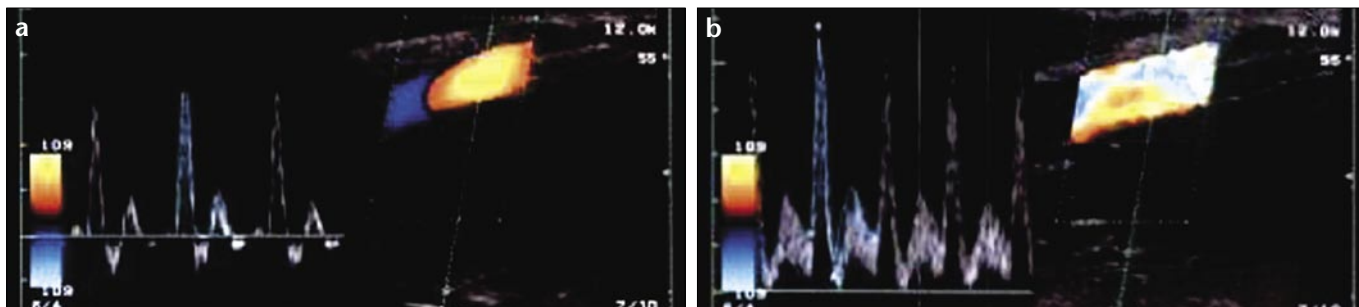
a, b. Submaximal exercise protocol. a. Color Doppler sonogram and spectral analysis of the brachial artery at rest shows triphasic flow pattern. b. After exercise, the flow assumes into a monophasic pattern with increased flow velocity and volume blood flow.
